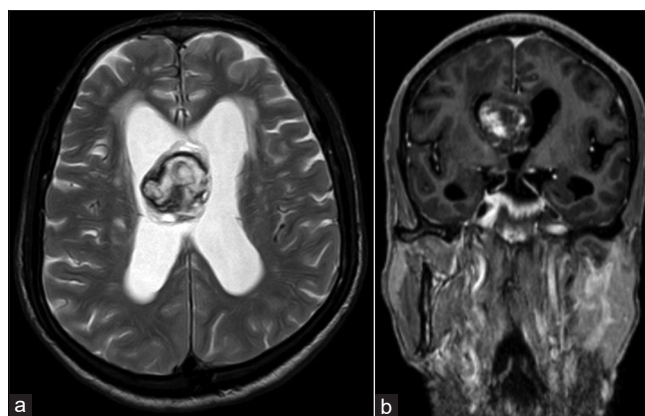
(a) Magnetic resonance imaging of brain axial section T2-weighted images showing a right ventricular mass of 3.5 cm × 2.8 cm. The lesion is well-defined, heterogeneously hyperintense with poor contrast enhancement. (b) Coronal T1-weighted magnetic resonance imaging showing areas of hemorrhage and obstruction of both foramina of Monro, causing biventricular hydrocephalus
